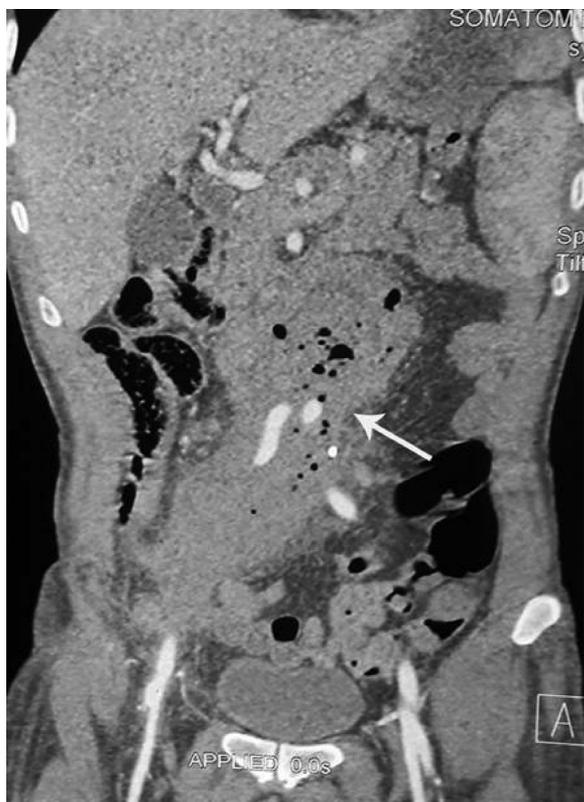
Contrast-enhanced computed tomography scan showing multiple air foci around opacified limbs of graft (case of aortoenteric fistula).
